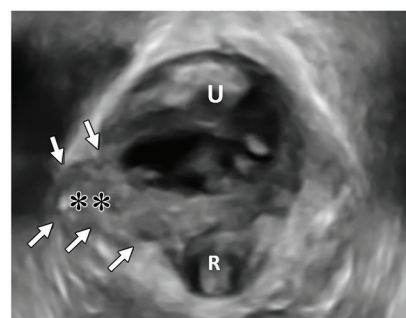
The levator ani at the level of the pelvic hiatus. *R* = rectum, *U* = urethra. (a) Axial 3D volume-rendered translabial US image shows a normal puborectalis muscle (\*). *SP* = symphysis pubis, *V* = vagina. (b) Axial T2-weighted MR image shows a typical right-side avulsion injury (arrowheads), with associated loss of the butterfly shape of the vagina (dashed line). (c) Axial 3D volume-rendered translabial US image obtained in the patient in b shows the right-side avulsion (arrows), with a gap (\*\*) between the muscle bundles.
